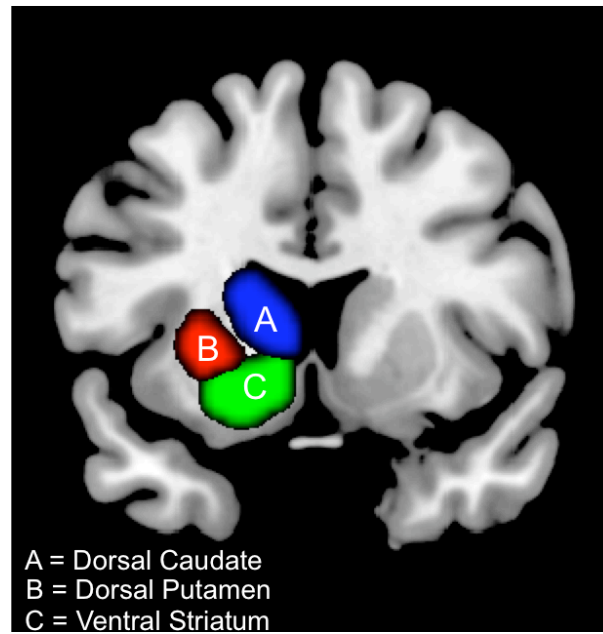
Striatal Regions of Interest (ROIs). ROIs rendered on a T1-weighted reference image, with a coronal slice at Y = 11 (MNI space). ROIs defined by anatomical criteria of Mawlawi et al (2001). Only pre-commissural ROIs are shown.
